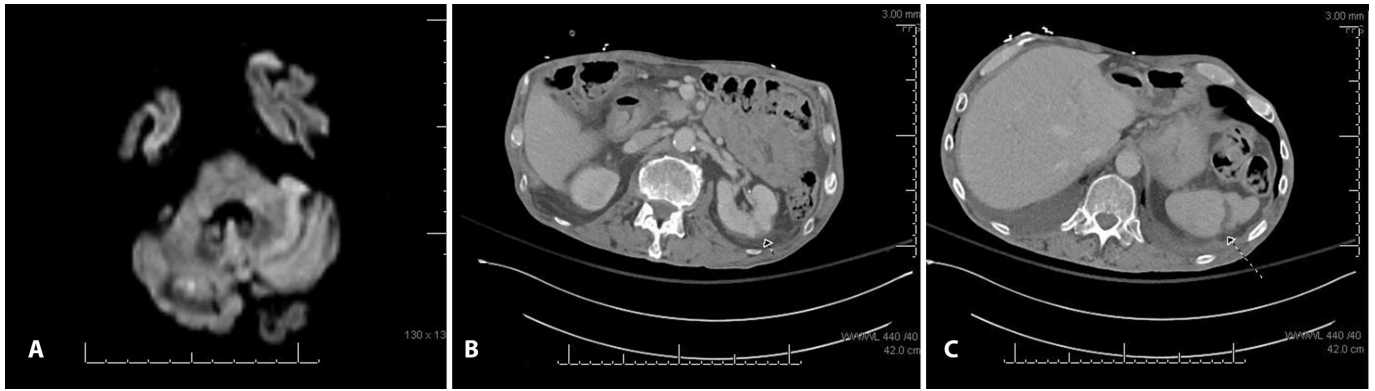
(A) Brain MRI showing a focus of restricted diffusion in right cerebellum. (B) CT of abdomen demonstrating wedge-shaped area of renal cortical hypoattenuation. (C) CT of abdomen demonstrating age-indeterminate splenic infarct.
